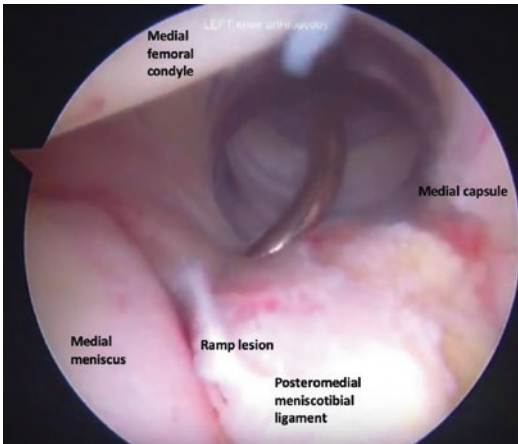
Arthroscopic image of ramp lesion. This image depicts a ramp lesion as seen through the Gillquist view during an arthroscopic anterior cruciate ligament reconstruction. The peripheral attachment of the posterior horn of the medial meniscus, specifically the posteromedial meniscotibial ligament, has been disrupted. MRI has varying sensitivity for detecting these lesions, and it is important to evaluate for them intraoperatively, as unstable ramp lesions may require additional surgical intervention
